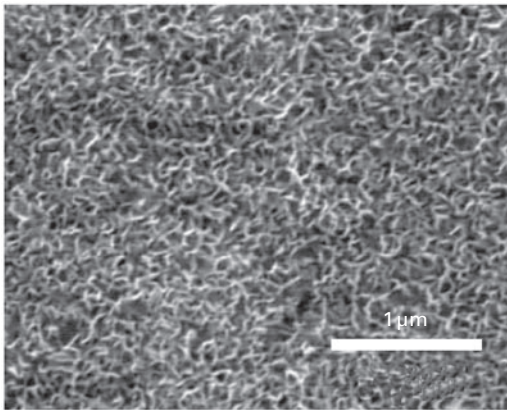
shows the surface morphologies of cpTi (Fig. 11.6(a)), Ti-120 (Fig. 11.6(b)) and Ti-240 (Fig. 11.6(c)). Leaf-like deposits with the size of ~100 nm consisting of anatase were observed on the Ti-120 surface. On the Ti-240 surface, pyramid-like anatase with the size of several hundred nanometers to several micrometers were observed. The anatase formation and its morphology were significantly related to the autoclaving temperature. The titania layers adhered strongly on the cpTi surface even after ultrasonic treatment in DW for 15 min, or a tape-test using Scotch<sup>®</sup>#6.
